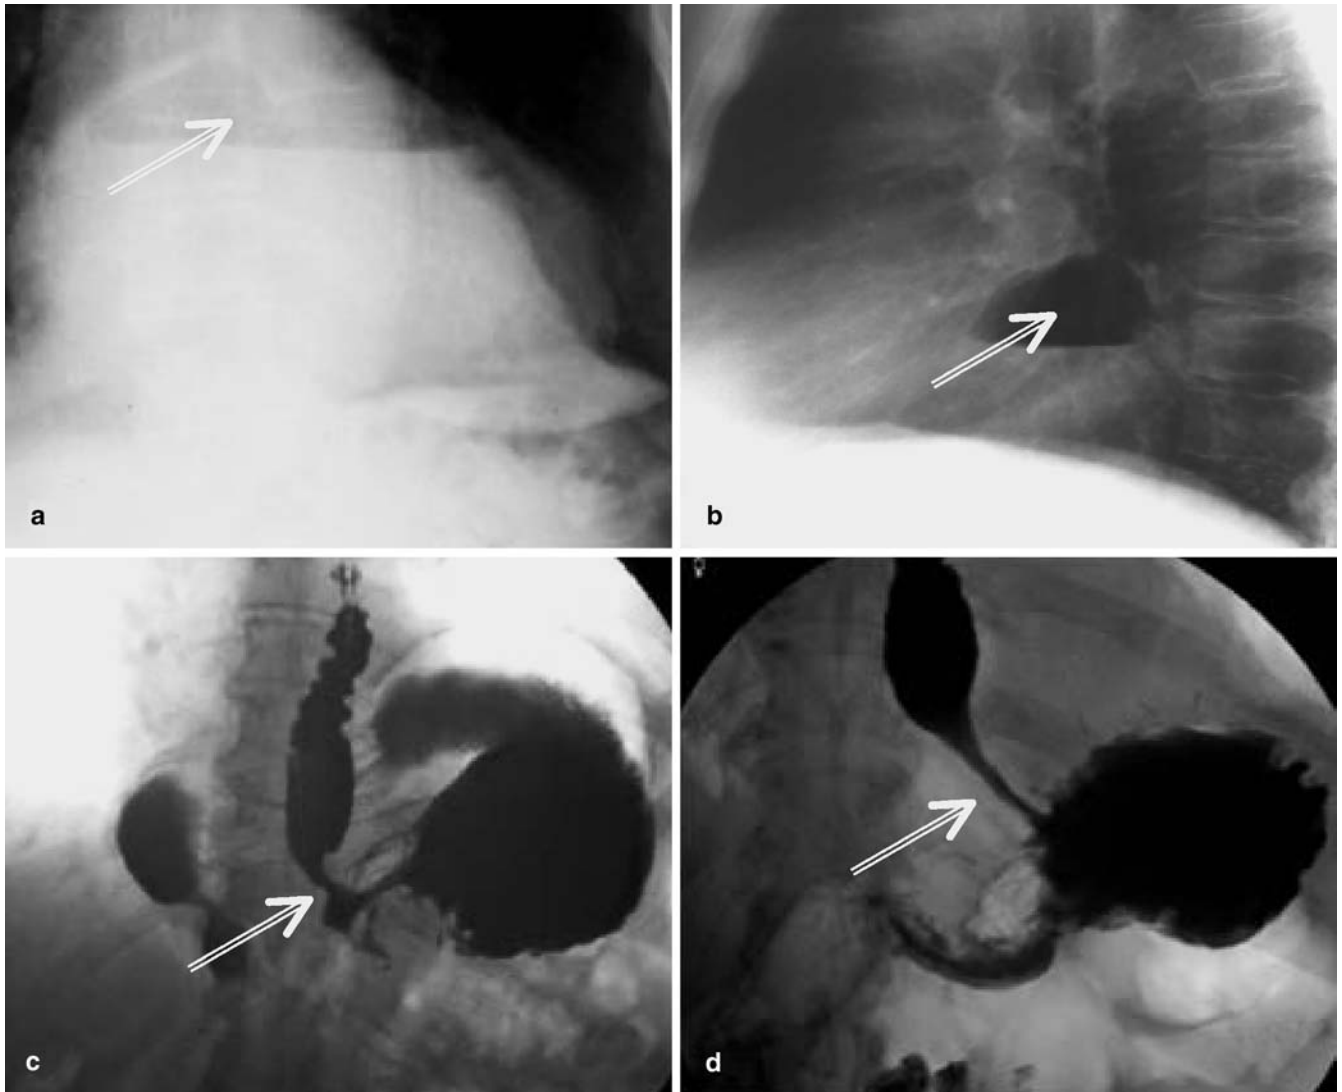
Preoperative and postoperative radiological diagnostics. a Preoperative chest X-ray; b preoperative chest X-ray lateral with mediastinal fluid levels (→); c preoperative gastrointestinal passage with mediastinal position of the stomach and gastro-oesophageal
